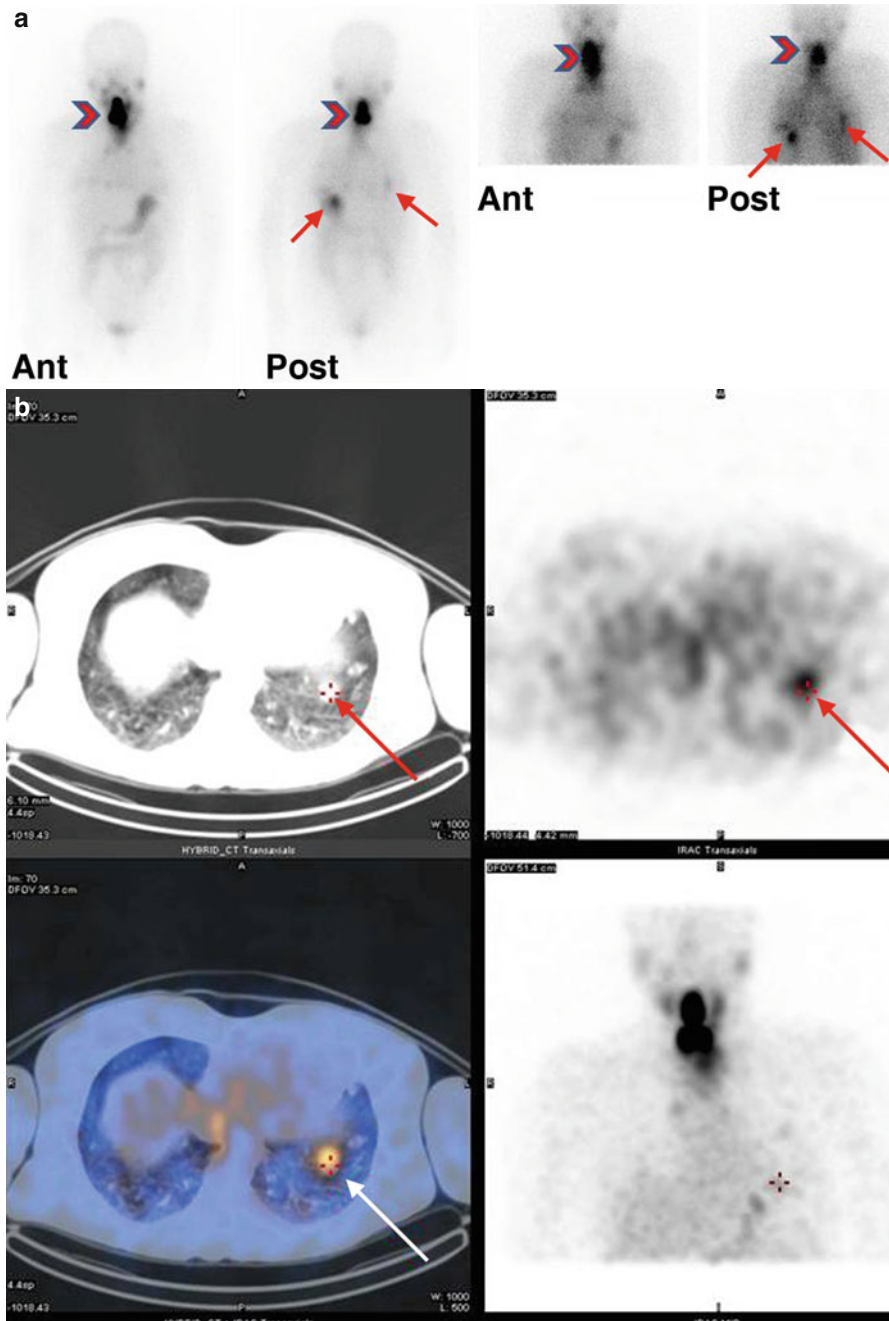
(a) Post-therapy scintigraphy which was performed 4 days after the administration of 200 mCi of I^{131} in a 40-year-old woman with papillary thyroid cancer along with low differentiated thyroid cancer (TSH, 31 uIU/ml; Tg, 4508 ng/ml; anti-Tg Ab <20 IU/ml) displays prominent radioiodine uptake around the neck region consistent with recurrent disease (*arrowhead*) as well as faint radioiodine uptake suggesting macronodular lung metastases (*arrows*). (b) Macronodular lung metastases are better delineated on SPECT/CT transaxial images (*arrows*)
